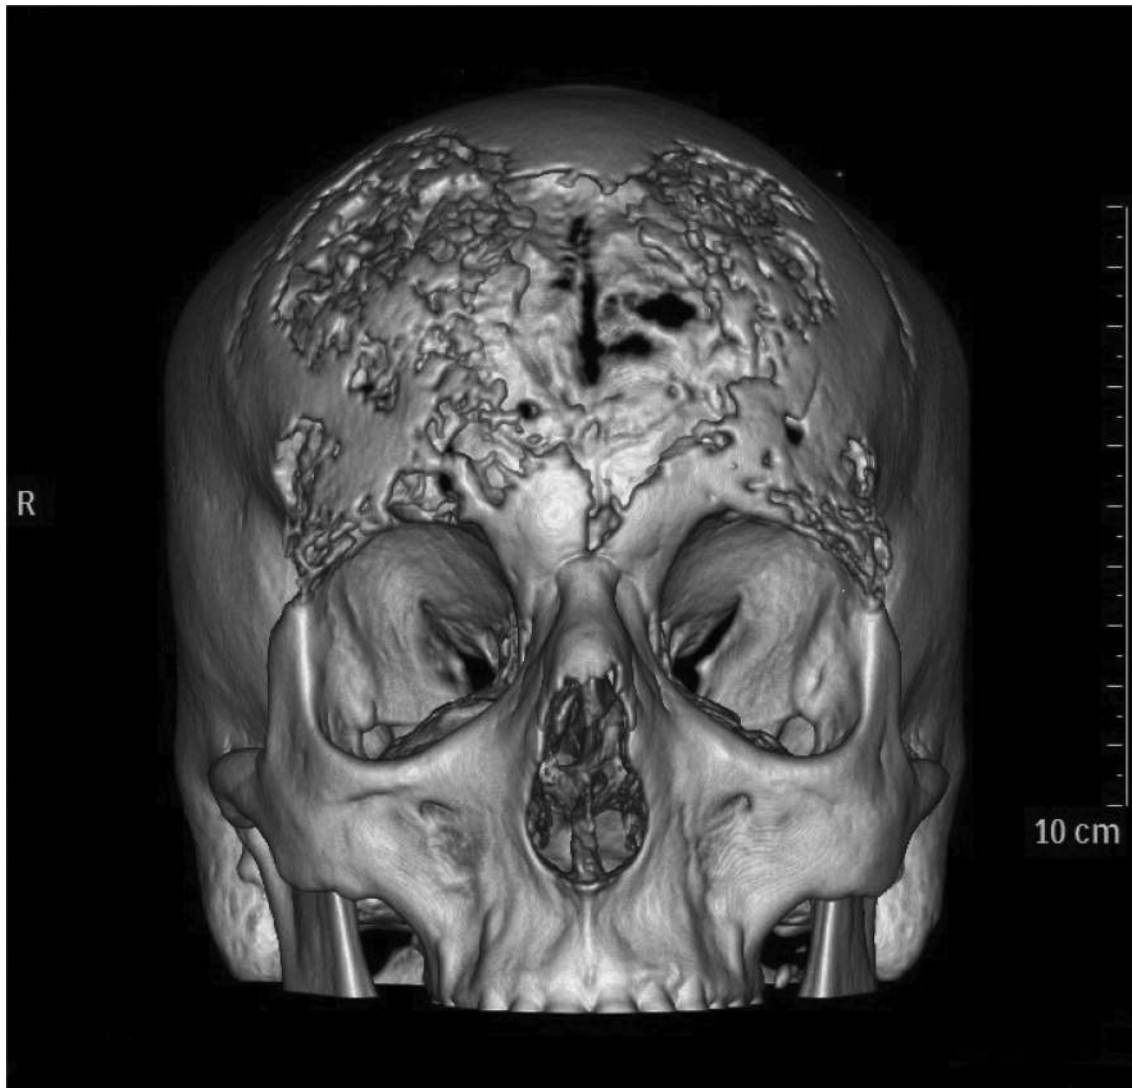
Computed tomography scan reconstruction image of skull osteomyelitis secondary to cutaneous mucormycosis (case 11).
